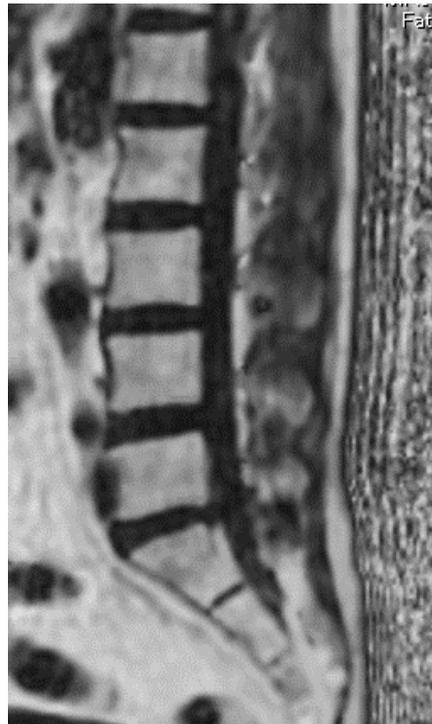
Sagittal proton density fat fraction (PDFF) map from chemical shift encoding-based water-fat magnetic resonance imaging (CSE-MRI). Sagittal-view CSE-MRI allowing measurement of PDFF in bone marrow of the fourth lumbar vertebral body.
